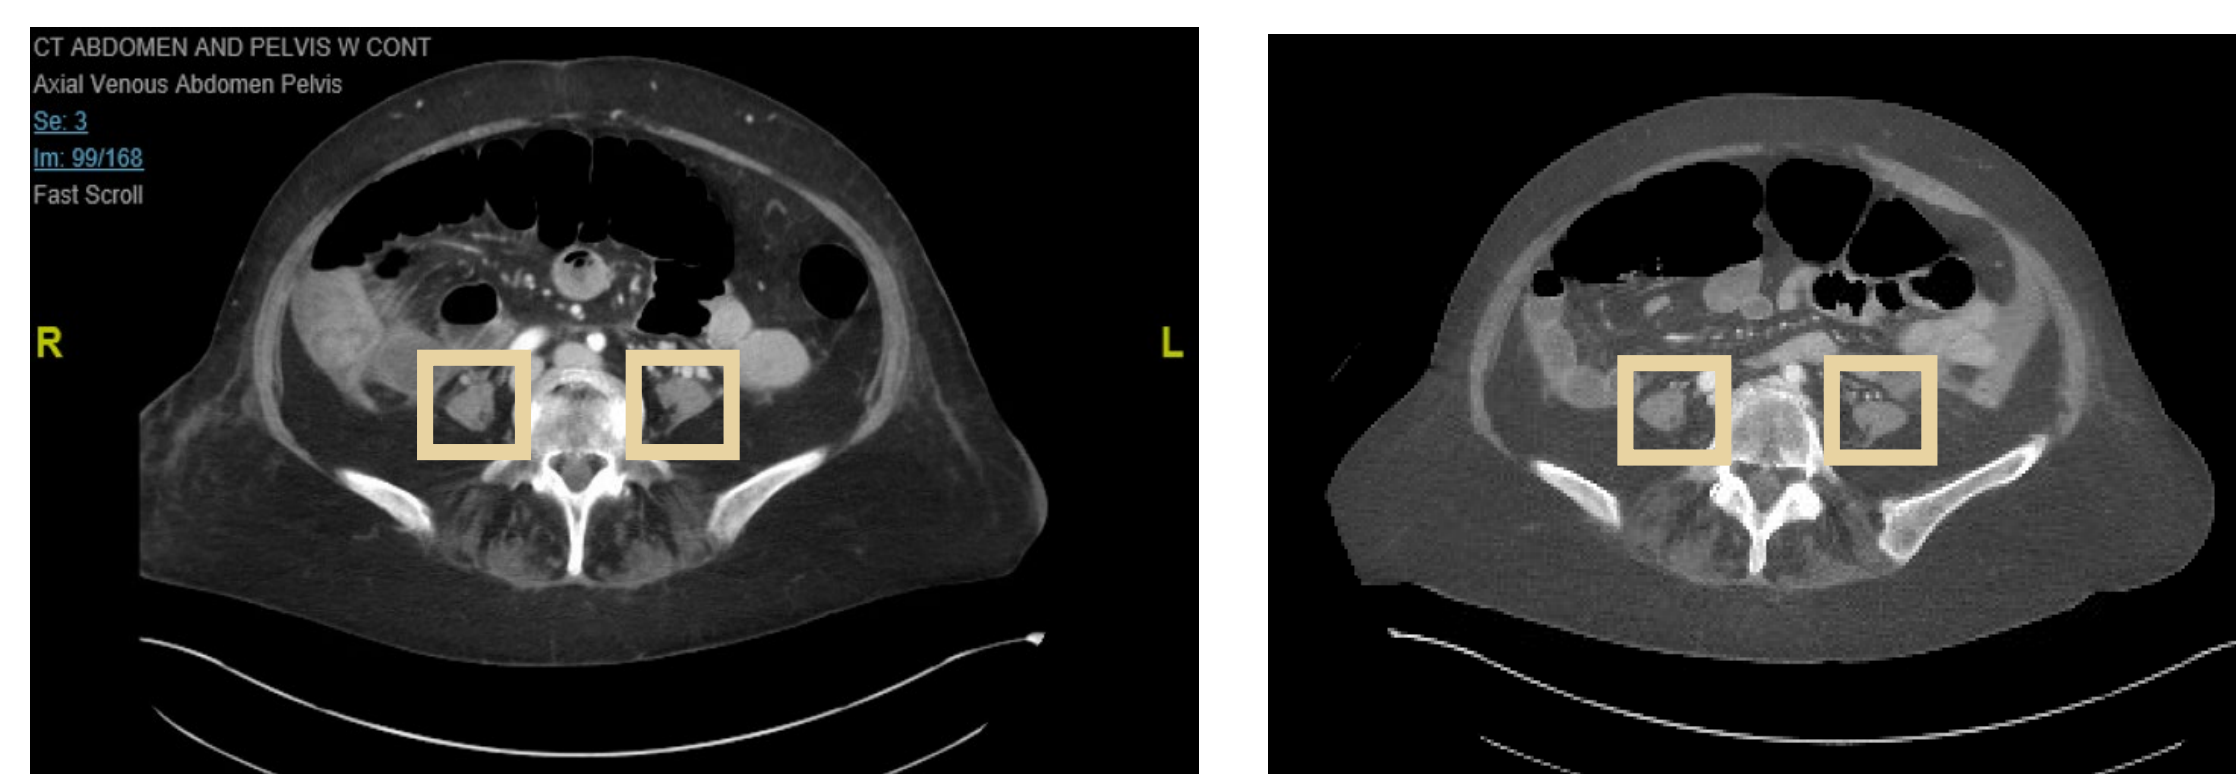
Axial abdominal CT scan of patient psoas muscle at the lumbar 4 region taken HD 37 (left) and HD 45 (right). The yellow boxes show the psoas muscles. The density decreased from 55.5 +/- 18 Hounsfield units (HU) to 46.0 +/- 11.5 HU. A normal psoas density is 50-60 HU.
